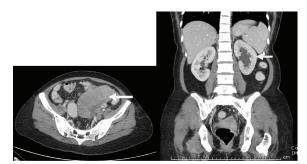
CT scan of the patient in Jan 2012 showed large lymphadenopathies along the left common iliac, left and right iliac regions (left image) as well as left hydronephrosis (right image).
